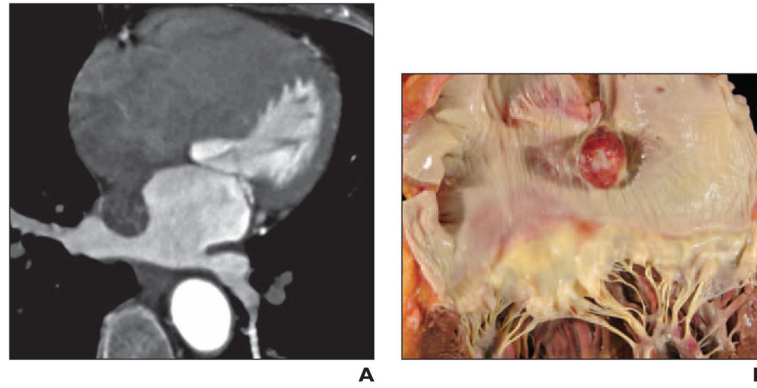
63-year-old man with history of coronary artery bypass grafting who was found to have left atrial mass at routine follow-up echocardiography
